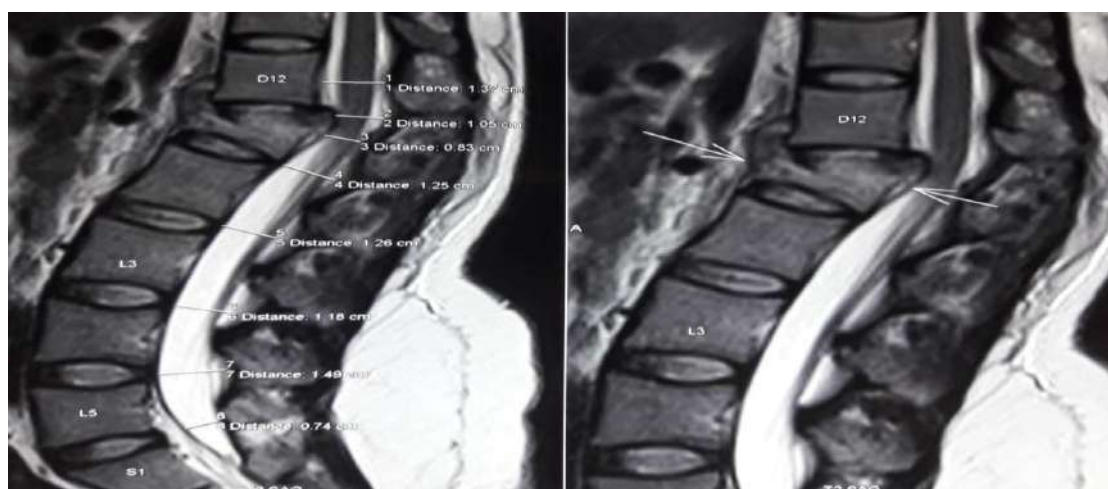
MRI lumbar spine showing compression of spinal cord by fractured L1 vertebra.
